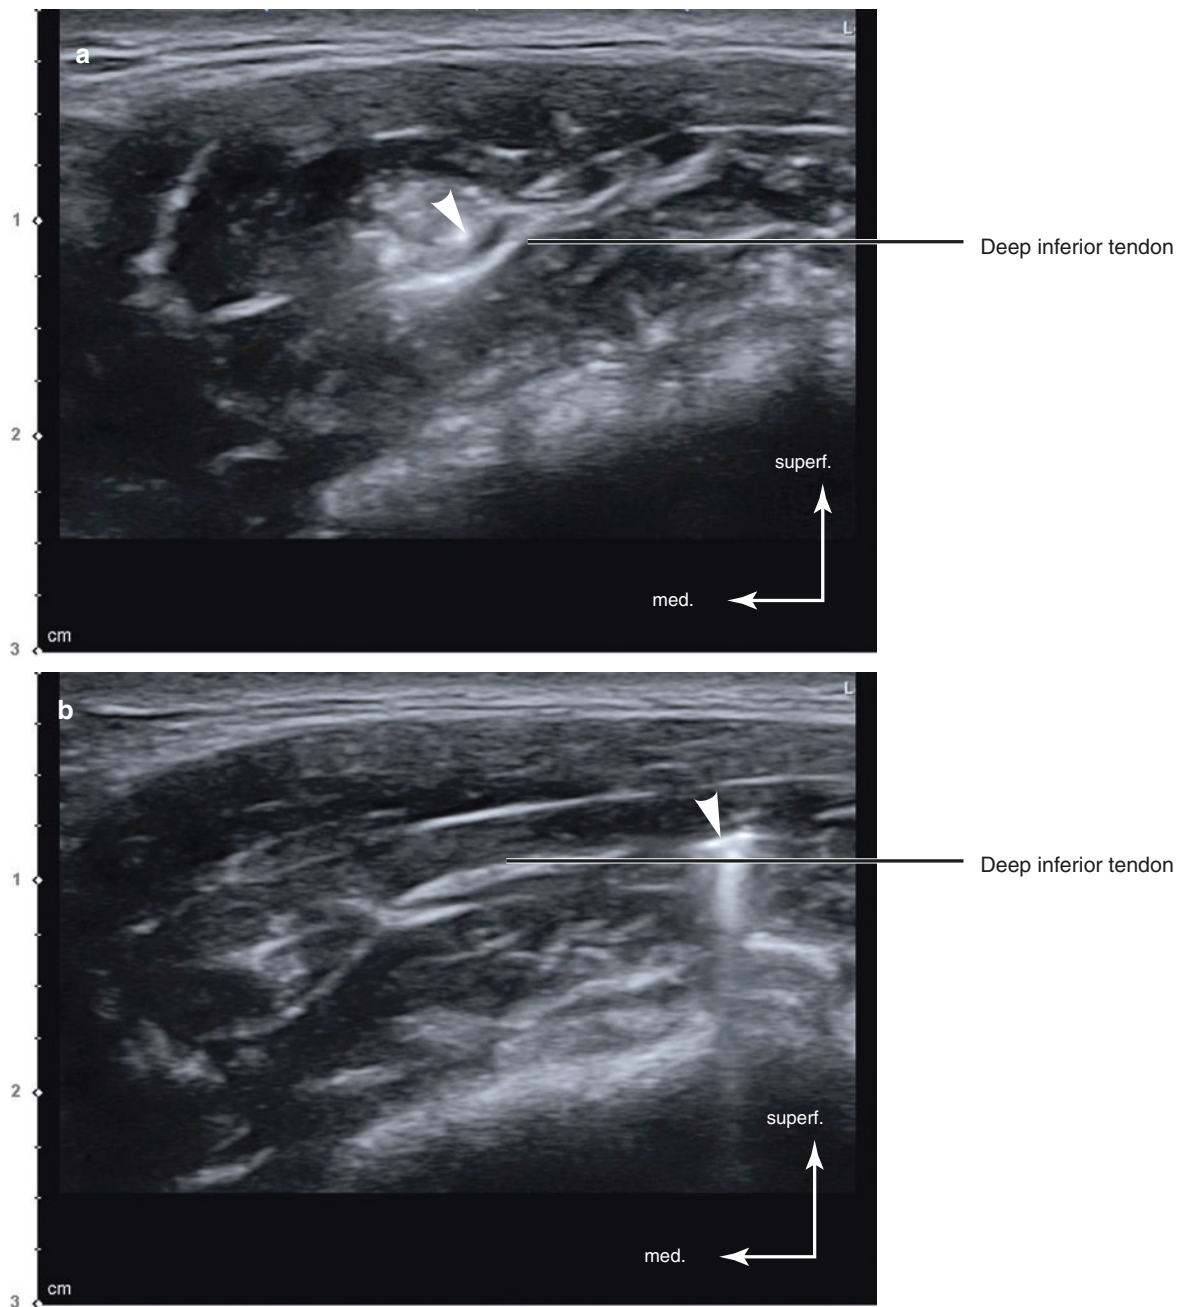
Ultrasonography-guided dual plane botulinum toxin injection to the masseter muscle. (a) Superficial injection (out-of-plane), B mode (transverse view, 15 MHz by linear transducer) and (b) deep injection
